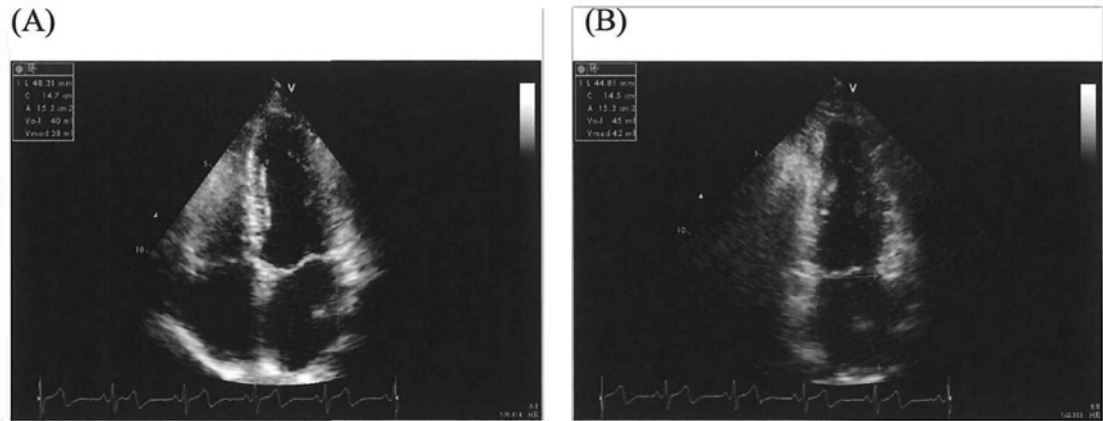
Example of measurement LA volume using Simpson's method. The maximal LA volume is measured at end-systole using apical four- (A) and two-chamber (B) views.
